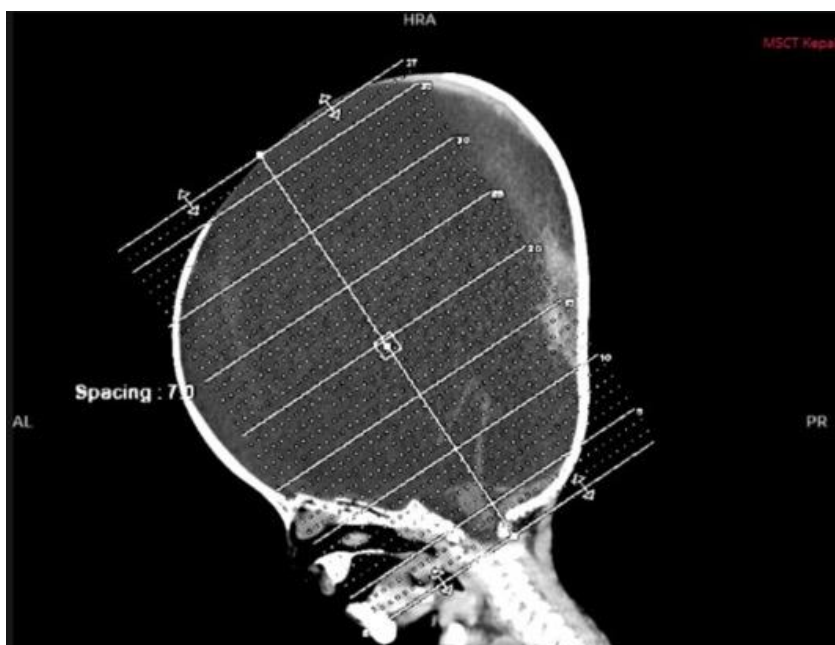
Non-contrast multislice computed tomography of the head (lateral view) showing a massively enlarged cranial vault disproportionate to the facial skeleton, consistent with severe communicating hydrocephalus and macrocephaly.
